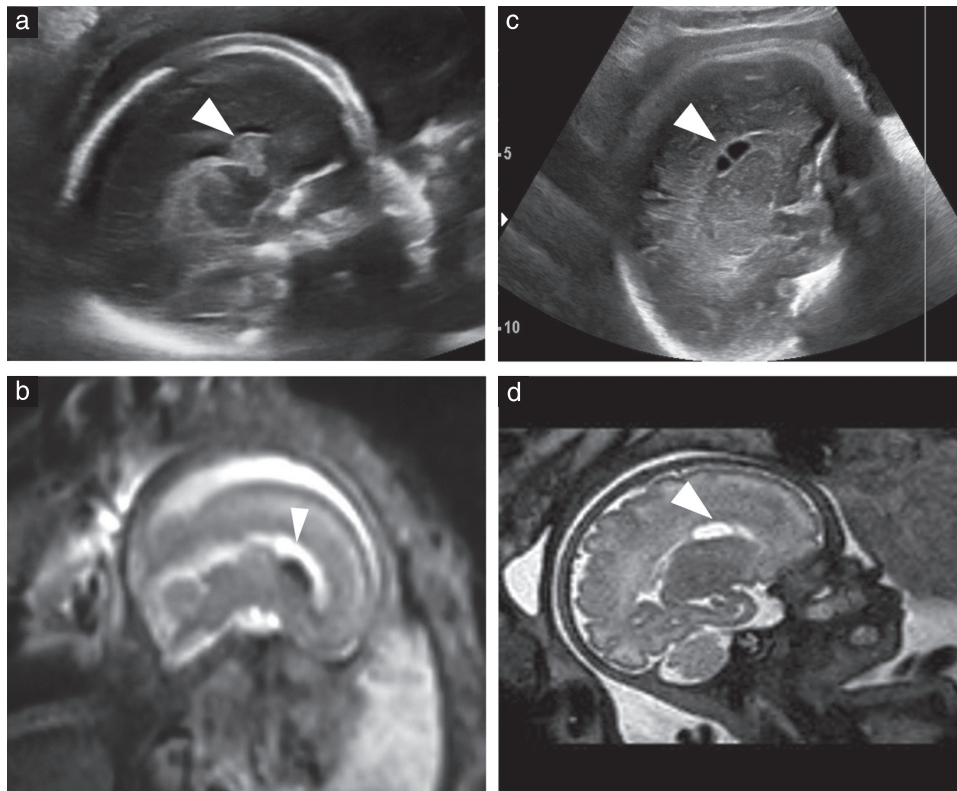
(a) Two-dimensional (2D) ultrasound image in parasagittal plane in fetus at 28 weeks' gestation (Case 3), showing hemorrhagic lesion (arrowhead) of germinal matrix; this was confirmed on antenatal magnetic resonance imaging (MRI) in same plane at same gestational age (b). (c) 2D ultrasound image in parasagittal plane in fetus at 34 weeks (Case 2), showing multiple cystic lesions (arrowhead) of germinal matrix; this was confirmed on antenatal MRI in same plane at same gestational age (d).
